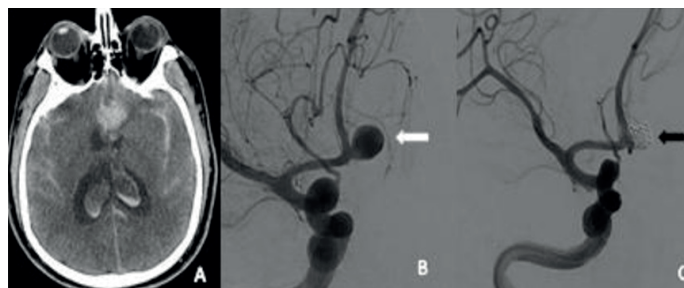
CT and procedural angiographic images of ACOM aneurysm causing subarachnoid hemorrhage. A. Subarachnoid hemorrhage that opens to the lateral ventricles in the interhemispheric fissure, bilateral sylvian fissures and sulcus. B. Narrow neck saccular aneurysm in ACOM localization (white arrow). C. Image after simple coil embolization into the aneurysm (black arrow)
